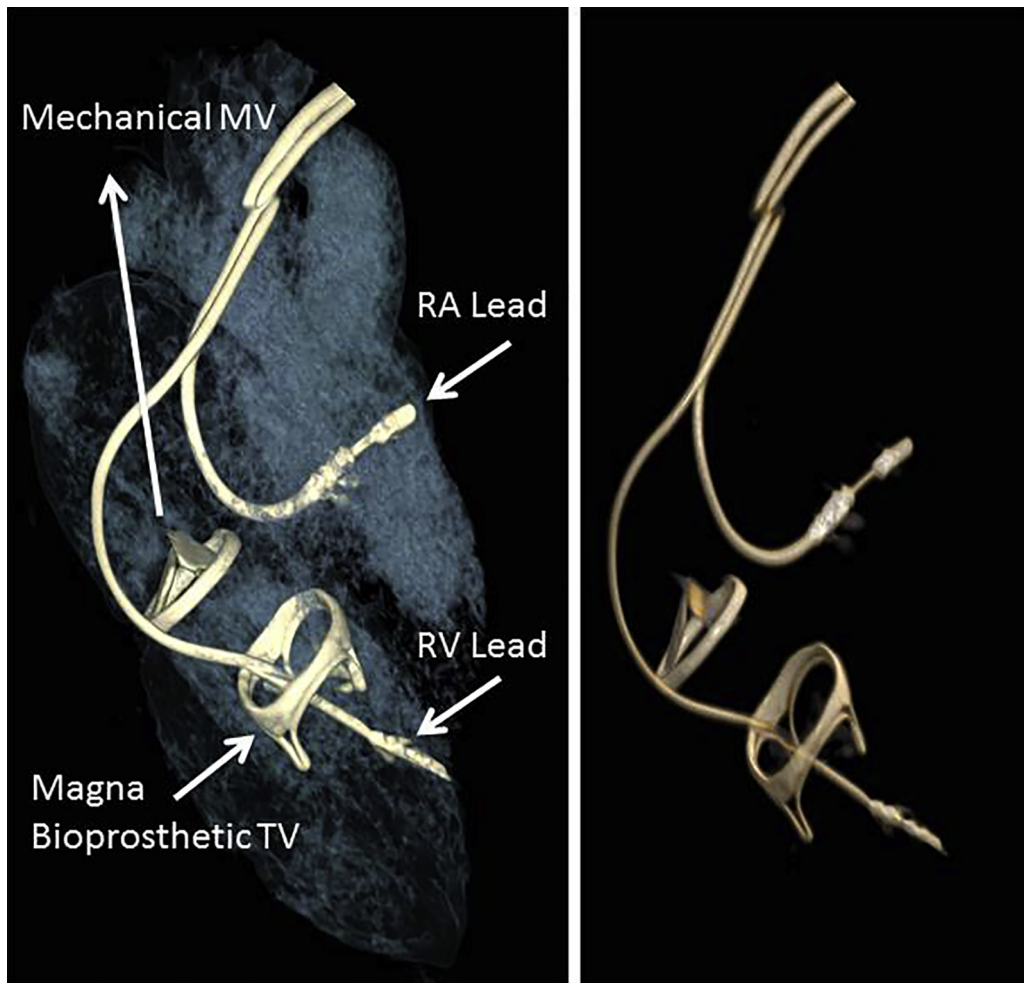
Cardiac computed tomography images: 3-dimensional volumetric reconstruction demonstrating the relationship of the tricuspid valve (TV) and mitral valve (MV) prostheses with the right atrial (RA) and right ventricular (RV) leads.
